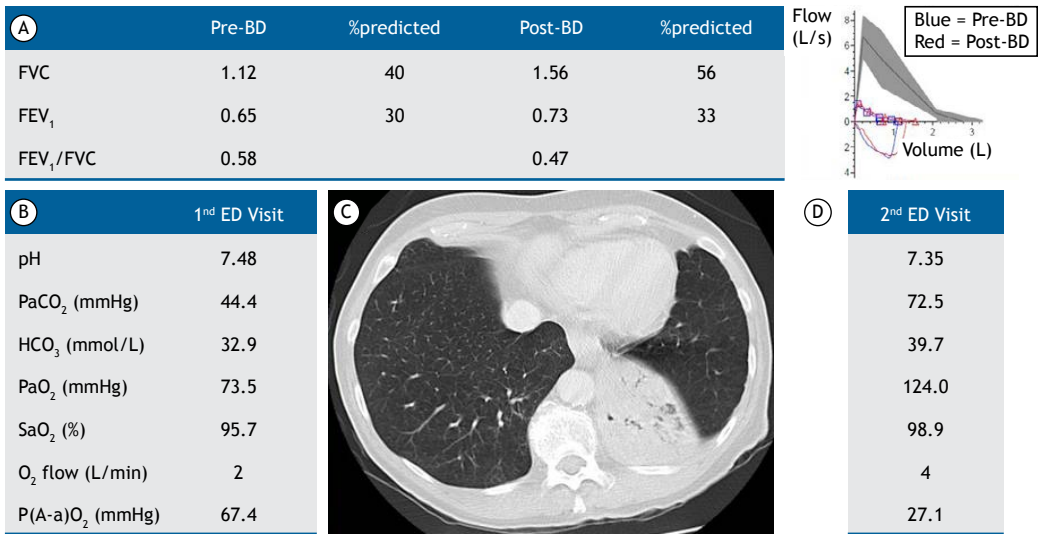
Baseline spirometry (in A) of a 71-year-old woman with a previous diagnosis of COPD who presented at the emergency department with worsening dyspnea and hypoxemia (baseline blood gas analysis in B). A CT pulmonary angiogram revealed pneumonia in the left lower lobe (Figure 1C), which explained an increased alveolar-arterial O₂ pressure gradient (expected value, 2.5 + [0.21 × age] = 17.4 mmHg). A few days after the resolution of pneumonia, a second arterial blood gas analysis showed lower alveolar-arterial O₂ pressure gradient and hypercapnia, as well as respiratory acidosis induced by the currently excessive high offer of O₂ at 4 L/min (in D). BD: bronchodilator; ED: emergency department; HCO₃: bicarbonate; and P(A-a)O₂: alveolar-arterial O₂ pressure gradient.
